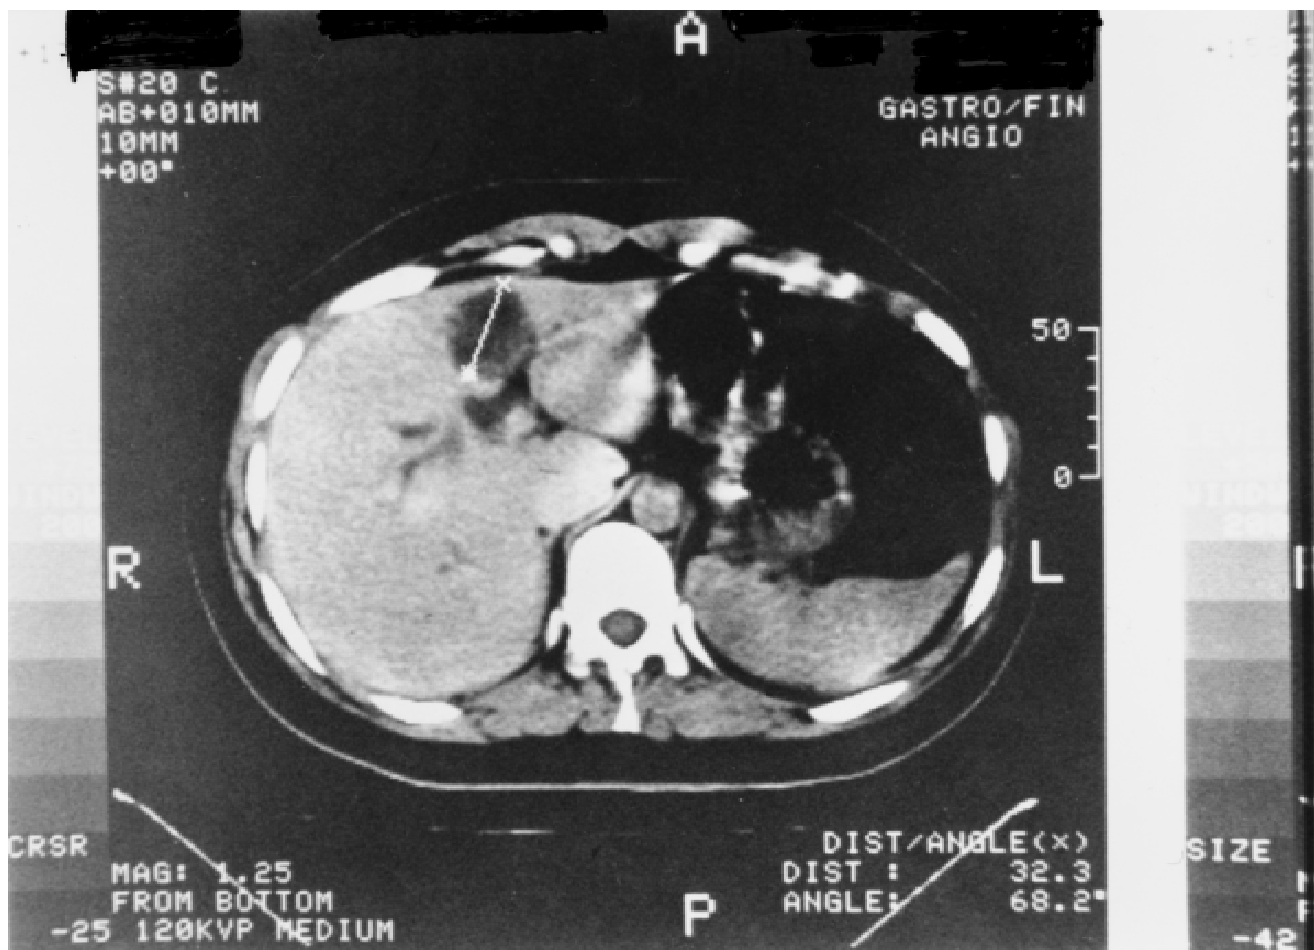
CT scan. Biliary cystadenoma in the visceral surface of the left lobe of the liver causing dilation of the biliary ducts proximally.
